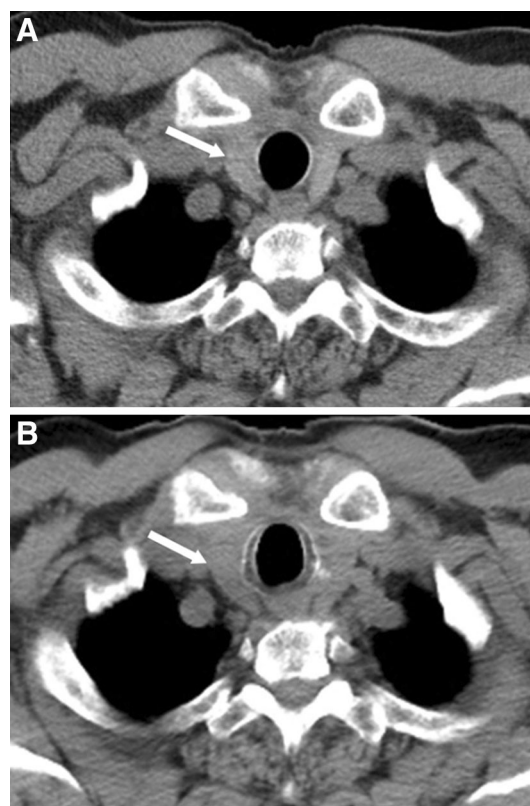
72-year-old man with history of poorly differentiated urothelial carcinoma of the bladder with pelvic nodal metastases, status post radical cystectomy. A Non-contrast axial CT image of the upper mediastinum shows normal size and density of the thyroid. B Follow-up CT after 12 weeks of treatment with PD-1 inhibitor shows diffuse interval enlargement of the thyroid and decreased density, which, in the context of altered thyroid function tests, suggested thyroiditis.
